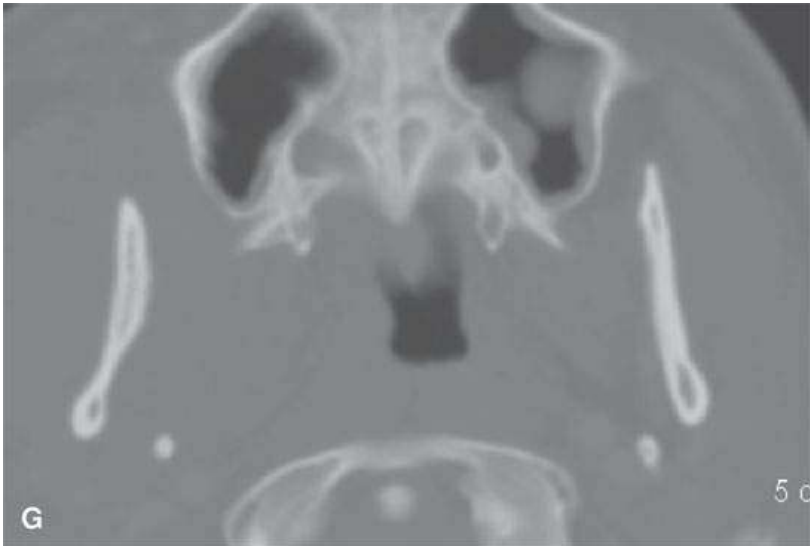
Computed tomography (CT) and magnetic resonance imaging of two patients with non-Hodgkin lymphoma of the masticator space. A: Contrast-enhanced CT of the lymphoma filling the masticator space and spreading to involve V3 at the foramen ovale and inferior alveolar branch of V3 at the mandibular foramen (*arrows*). B: Non-contrast-enhanced T1-weighted (T1W) image correlating with (A) (*arrow*) showing foramen ovale involvement. C: Non-contrast-enhanced T1W image showing tumor filling the masticator space and eroding the mandible (*arrow*). D: Non-contrast-enhanced T1W image of the lymphoma involving V3 at the mandibular foramen (*arrow*). E: CT at bone windows correlating with (D) and showing invasion of inferior alveolar branch of V3 at the mandibular foramen (*arrows*). F, G: Contrast-enhanced CT showing more diffuse masticator space involvement in a second patient by a slightly enhancing (as compared to nonenhancing) lymphoma (*arrows*) with no visible bony mandibular changes.
